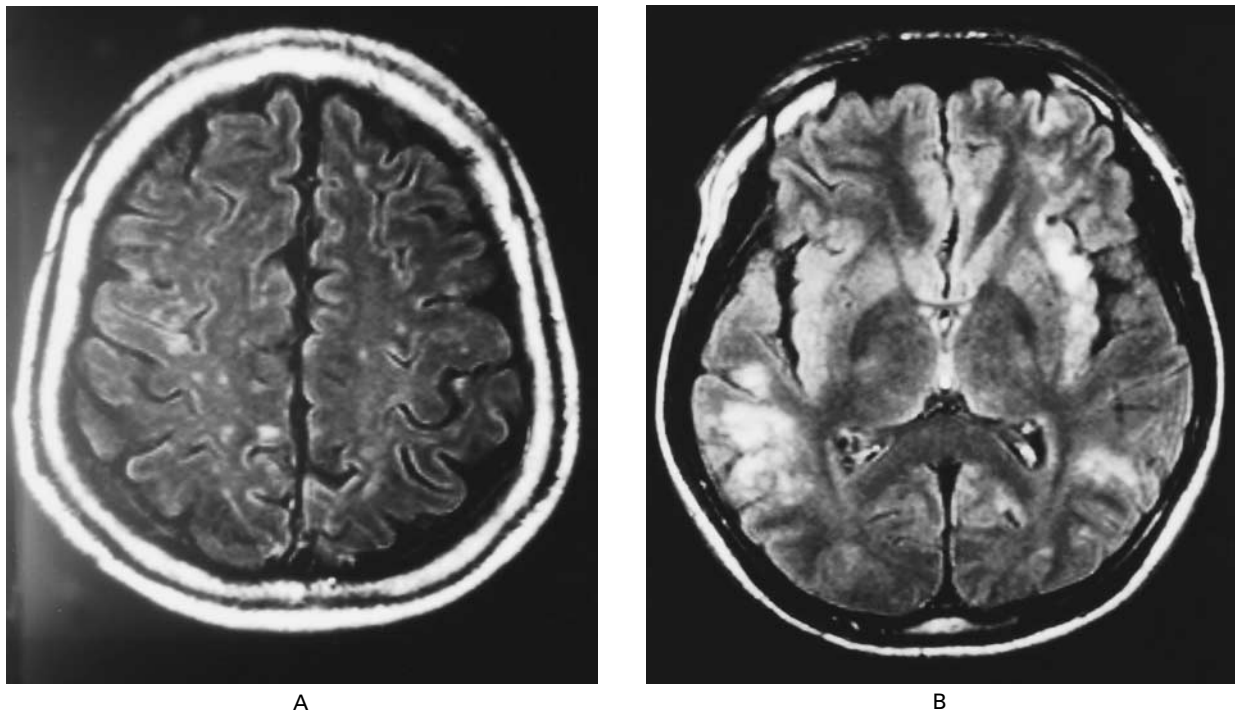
Axial MRI Findings in Patients with Acute (Panel A) and Relapsed (Panel B) Nipah Virus Encephalitis with Use of Fluid-Attenuated Inversion Recovery.
